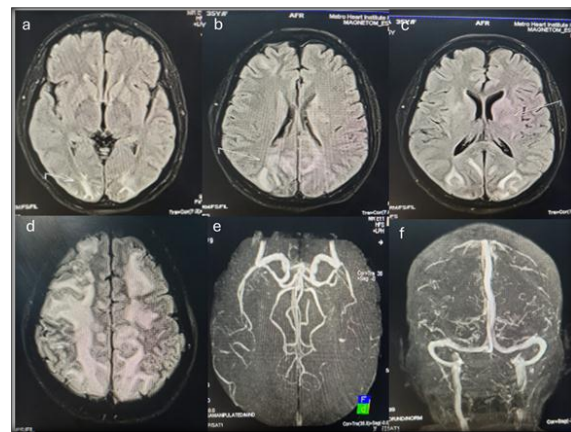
Imaging findings suggestive of Posterior reversible encephalopathy syndrome (PRES) in this case: Axial FLAIR weighted MRI image (a, b, c) and T2 weighted MRI image (d) showing high signal intensity of the cortical/subcortical location and deep white matter of bilateral frontal-parietooccipital lobes with involvement of the centrum semiovale, corpus callosum and patchy involvement of the left basal ganglia; MR angiography (e) showing no acute infarcts; MR venography (f) not showing any venous thrombus.
